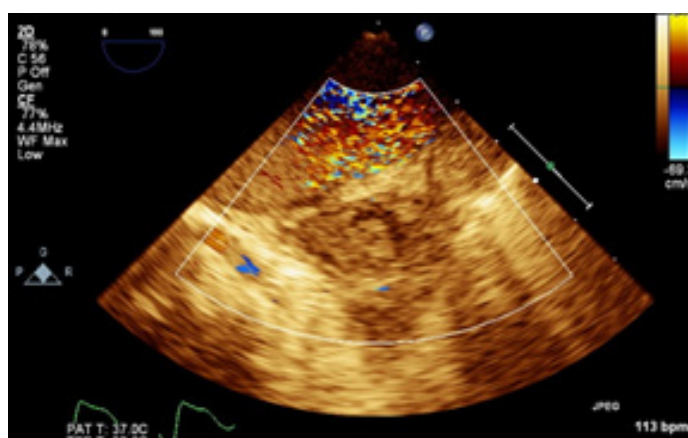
Doppler evaluation confirmed lack of flow into or out of the LA appendage.
